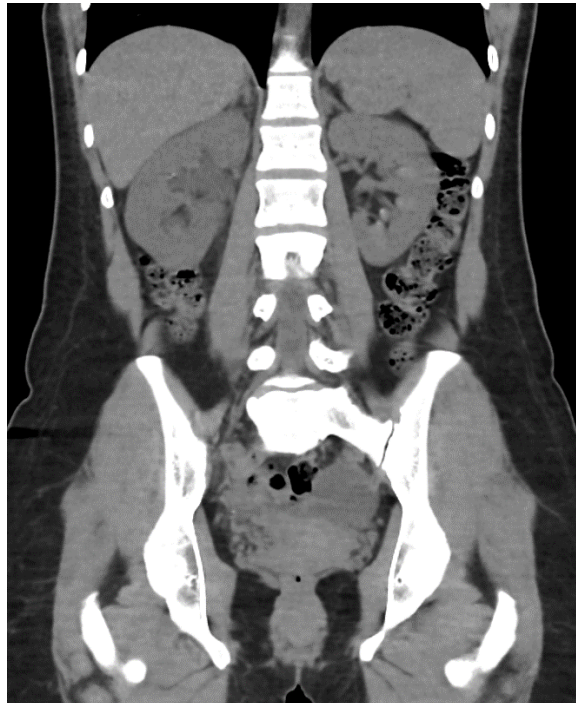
Coronal CT Image of a Patient with Moderate Hydronephrosis of the Right Kidney According to the Fetal Urology Society Classification.
